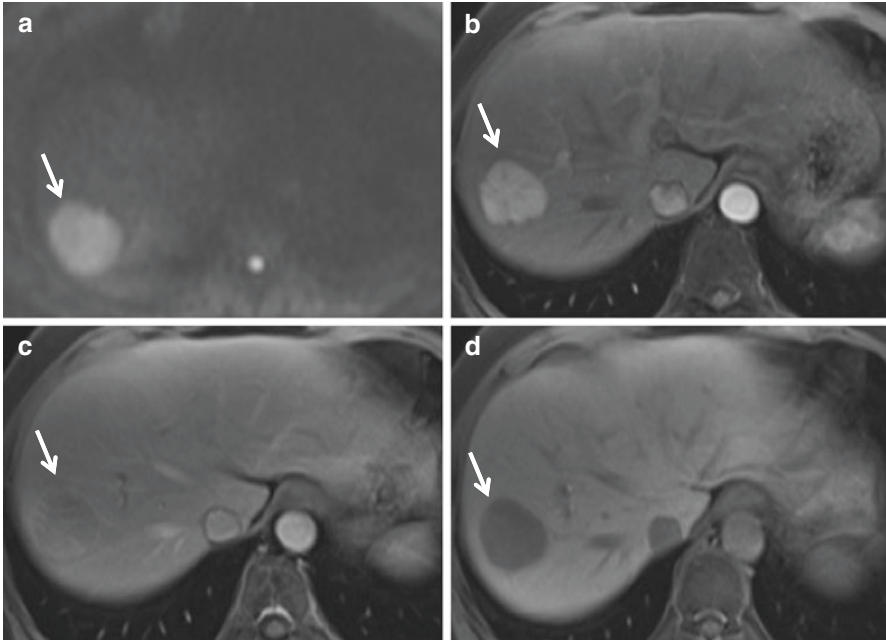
A 72-year-old male noncirrhotic patient with chronic hepatitis B virus infection and HCC. DWI demonstrates right hepatic lobe lesion with diffusion restriction (a, hyperintense on high b-value image b800, arrow). Axial T1-weighted image demonstrates strong arterial hyperenhancement (wash-in) during arterial phase (b, arrow), washout during portal venous phase with capsule enhancement (c, arrow), and hypointensity at hepatobiliary phase post-gadoxetic acid injection (d, arrow), diagnostic for HCC in the setting of chronic liver disease
